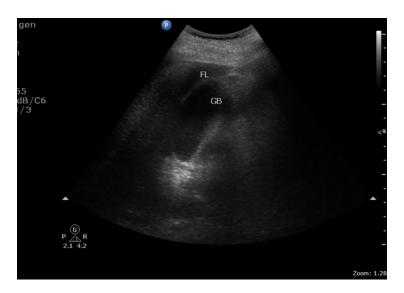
Ultrasound abdomen showing gallbladder wall thickening, fatty liver and ascites.
